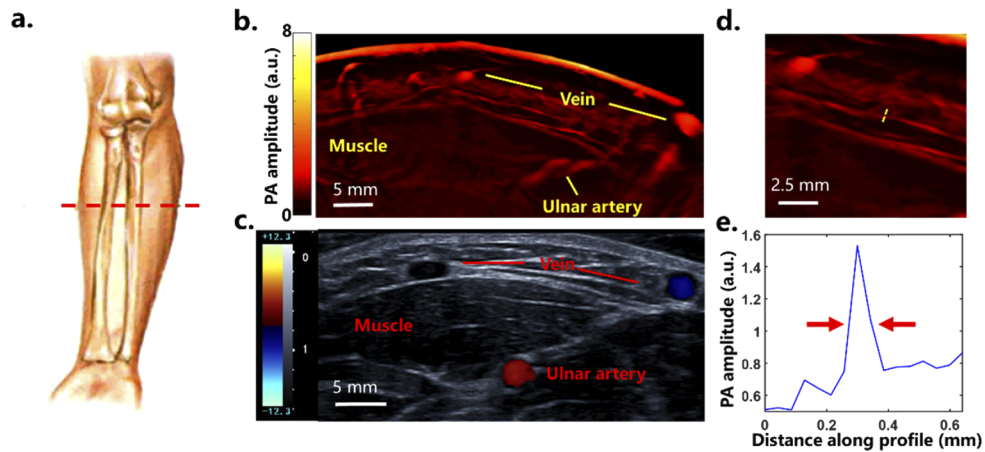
shows a side-by-side comparison between an anatomical cross-sectional US image (iNSIGHT 23R, Saset Healthcare, Inc. Chengdu, China) and a PAT image (800 nm) at rest state before the trial. A layer of strong signal from the skin with an underlying layer of adipose tissue with low PA signal appeared here. Below the adipose region, layers of small blood vessels were observed in the PA images which were not visualized in the US images. Because of the low scattering of ultrasound waves, the in-plane resolution of our PA images system is about  $\sim 150$   $\mu\text{m}$  in theory [29,35]. One small vessel was selected to measure the resolution of our PA images labeled by yellow dashed line in Fig. 2(d). The PA amplitude distribution along the yellow dashed line showed that the full width at half maximum (FWHM) of the profile was about 150  $\mu\text{m}$  shown in Fig. 2(e).
